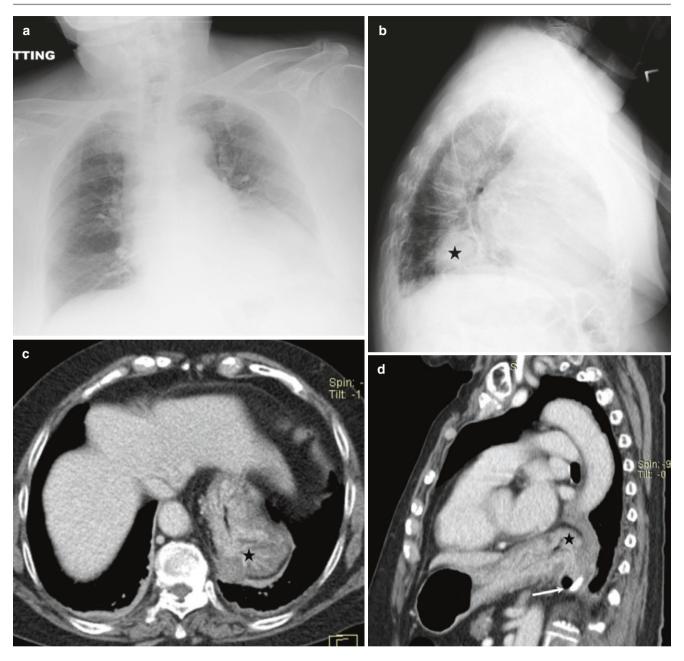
Rolling hiatal hernia. (\mathbf{a} , \mathbf{b}) Frontal and lateral chest radiographs show a retrocardiac opacity (asterisk) with curvilinear lucency around it. (\mathbf{c} , \mathbf{d}) Axial and sagittal CT images show herniated segment
